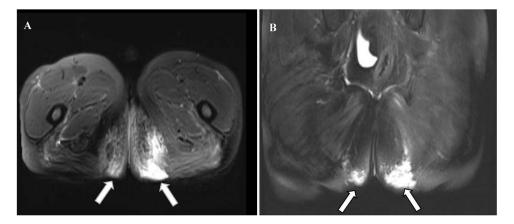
Figure I Pelvis MR images on admission.
